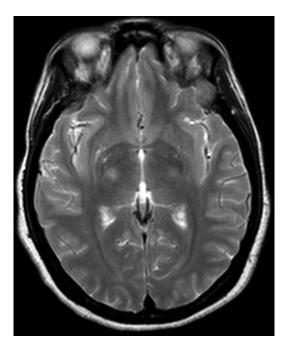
Axial T2-weighted MRI of the brain showing involvement of the right thalamocapsular region.
